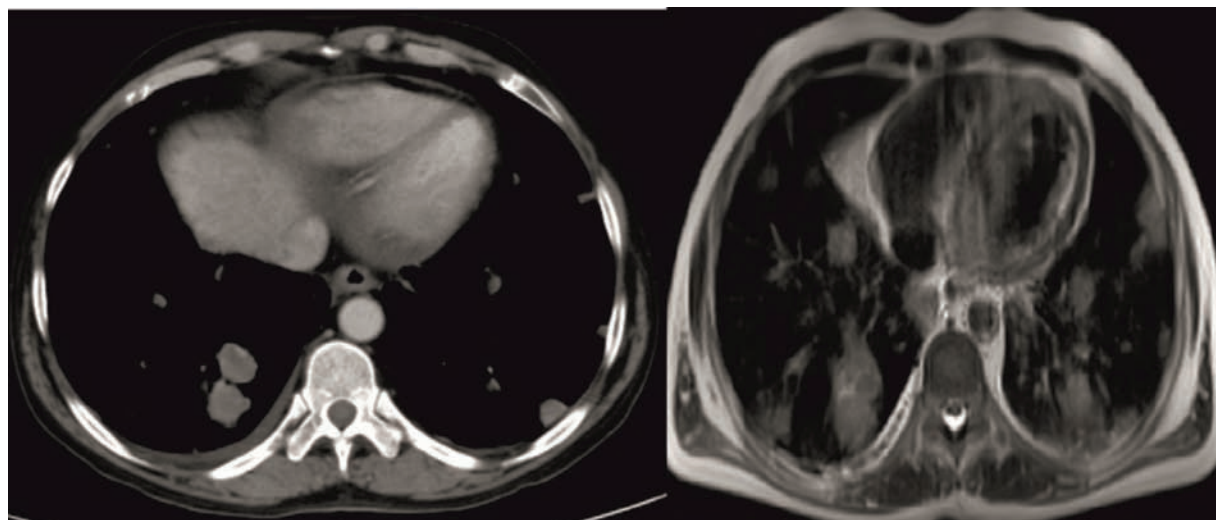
Axial CECT image (mediastinal window) (left) & axial non-fat-suppressed T2W MRI image (right) showing multiple tumor nodules in bilateral lower lobes
